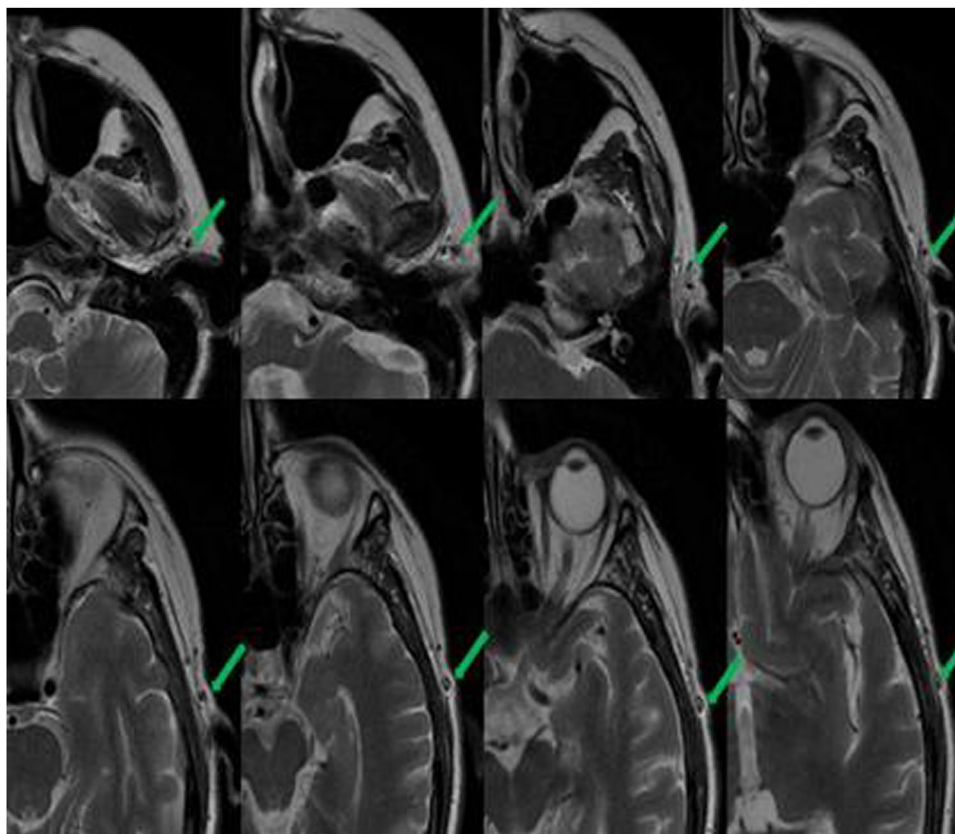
Axial T2 magnetic resonance imaging demonstrating the course of the superficial temporal artery all the way down to the internal maxillary artery (green arrows).
